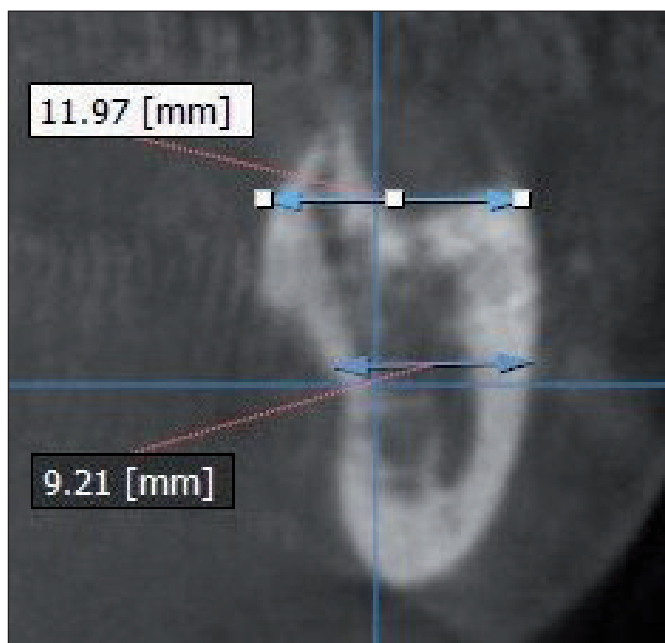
Bone width on CBCT.
